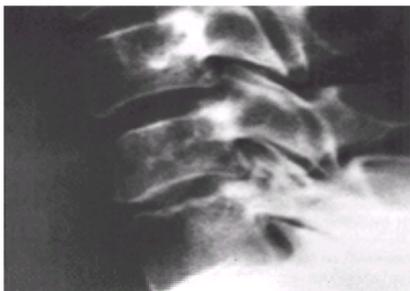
Lateral radiograph of the lower cervical spine, showing diminished height of the disc space, in a patient with brucellar spondylitis
